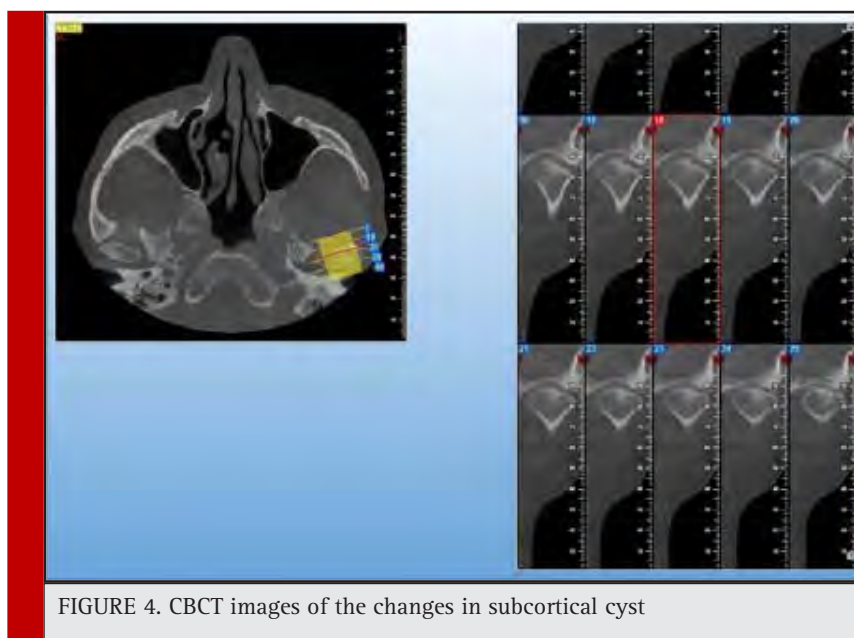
CBCT images of the changes in subcortical cyst
